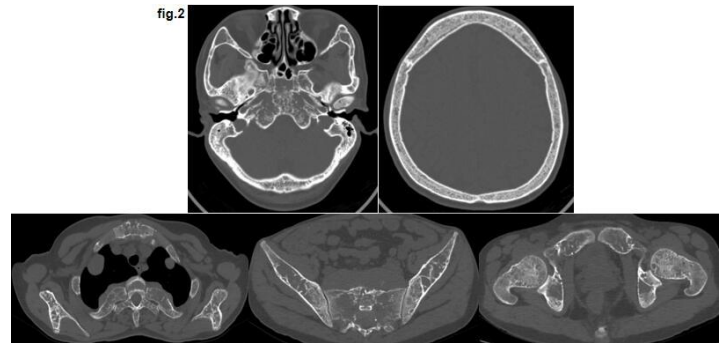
The CT showed the diploic spaces in craniofacial bones widened with cortical thinning, loose bone resorption and osteopenia. The CT (bone window) demonstrated multiple bones change with cortical bone thinning, marrow cavity widening and trabecula sparsely reticulating, which were shown in the sternum, ribs, scapula, vertebra and pelvic bones, etc.
